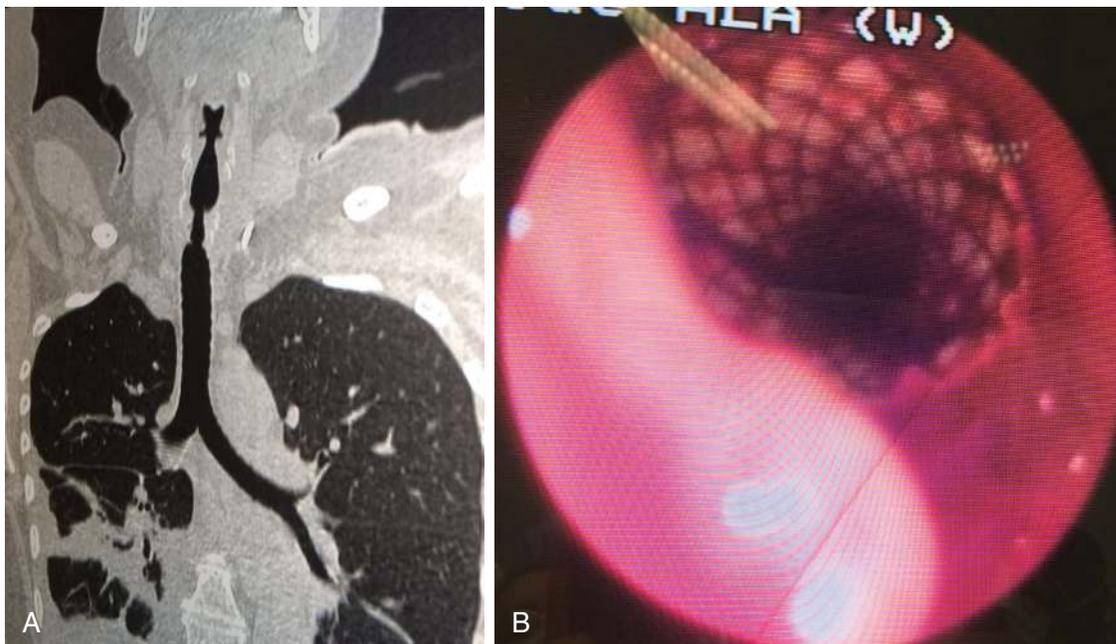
A, CT scan of moderate stenosis as a consequence of prolonged laryngeal intubation involving the subglottic region. B, Laser-assisted endoscopy with stenting to allow stabilization of the tracheal wall without airway control by temporary tracheostomy.
